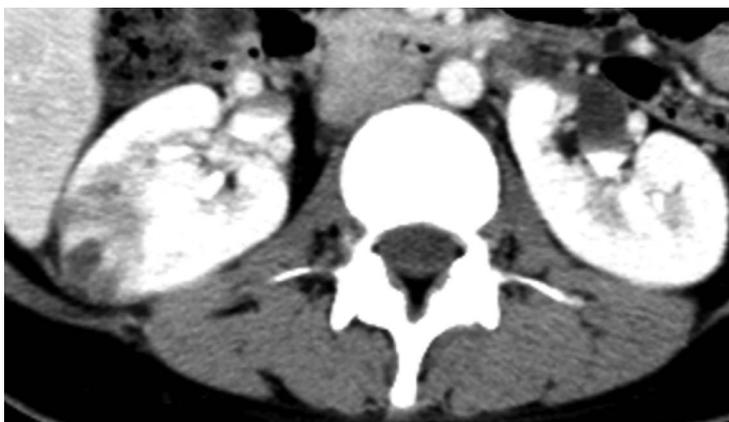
CT scan with contrast.
